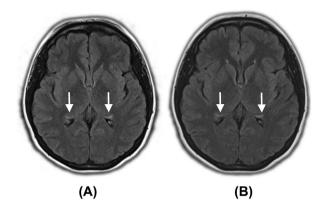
Panel A: An example slice from patient CK's MRI at day 1 of presentation, read as normal by neuro-radiology; however, on retrospect, possible subtle T2 FLAIR signal in the bilateral hippocampi was noted. Panel B: An example slice from patient CK's MRI 2 weeks after initial presentation; as per neuro-radiology, there is subtle high signal on FLAIR in the bilateral hippocampi. Although subtle, bilateral FLAIR T2 signal can be seen in anti-NMDA receptor encephalitis.
